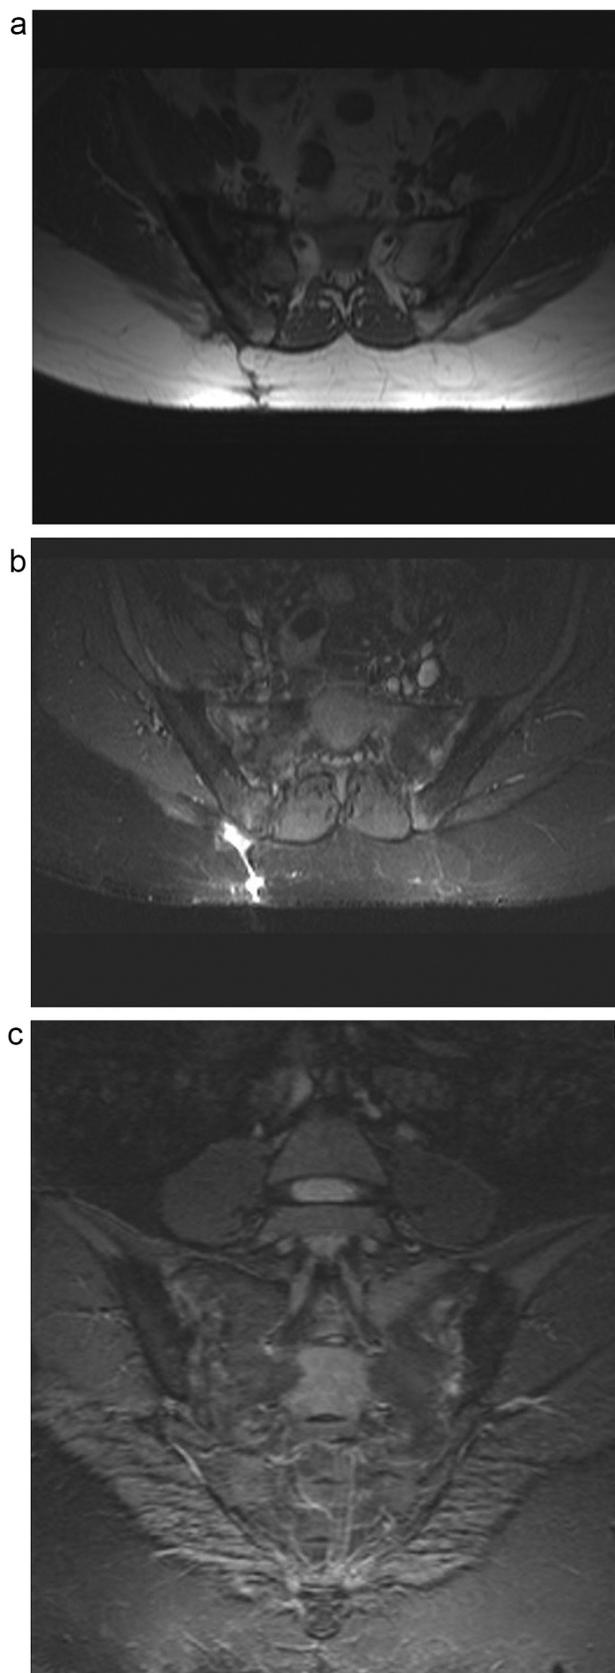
MRI of sacrum, SI joint, and adnexa at 6th month of follow-up (A, B, and C) axial T1, T2, and coronal T1 images, respectively. Showing a decreased joint space, marrow sclerosis, and no residual abscess. Mild hyper-intensity
